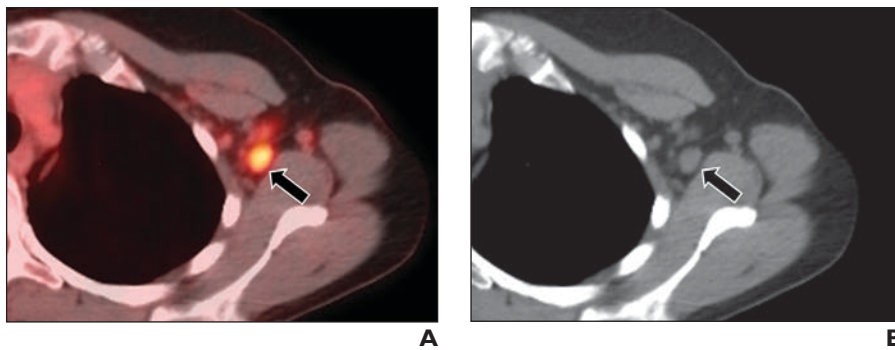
40-year-old woman 3 days after Moderna COVID-19 vaccination. A and B, Axial attenuation correction CT (A) and fusion (B) images from FDG PET/CT show rounded morphology with loss of fatty hilum in mildly enlarged FDG-avid left axillary lymph node (arrows).
